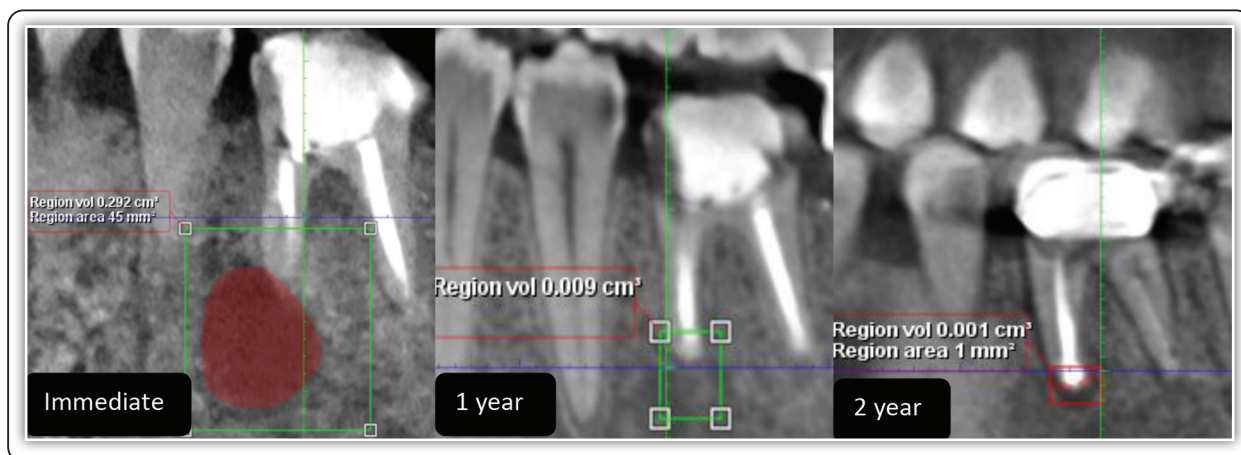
Showing A CBCT scans at immediate ,1 year and after 2 year.
